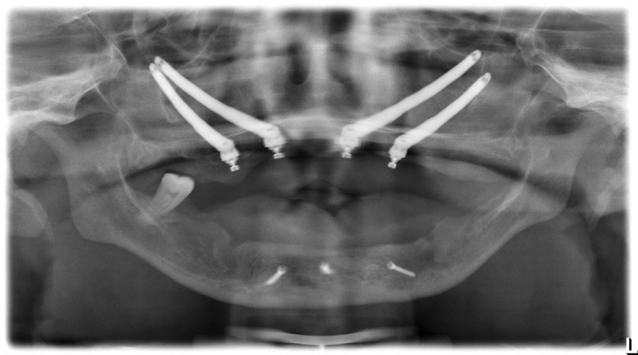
Panoramic radiograph showing the placement of four zygomatic implants and onlay graft.
